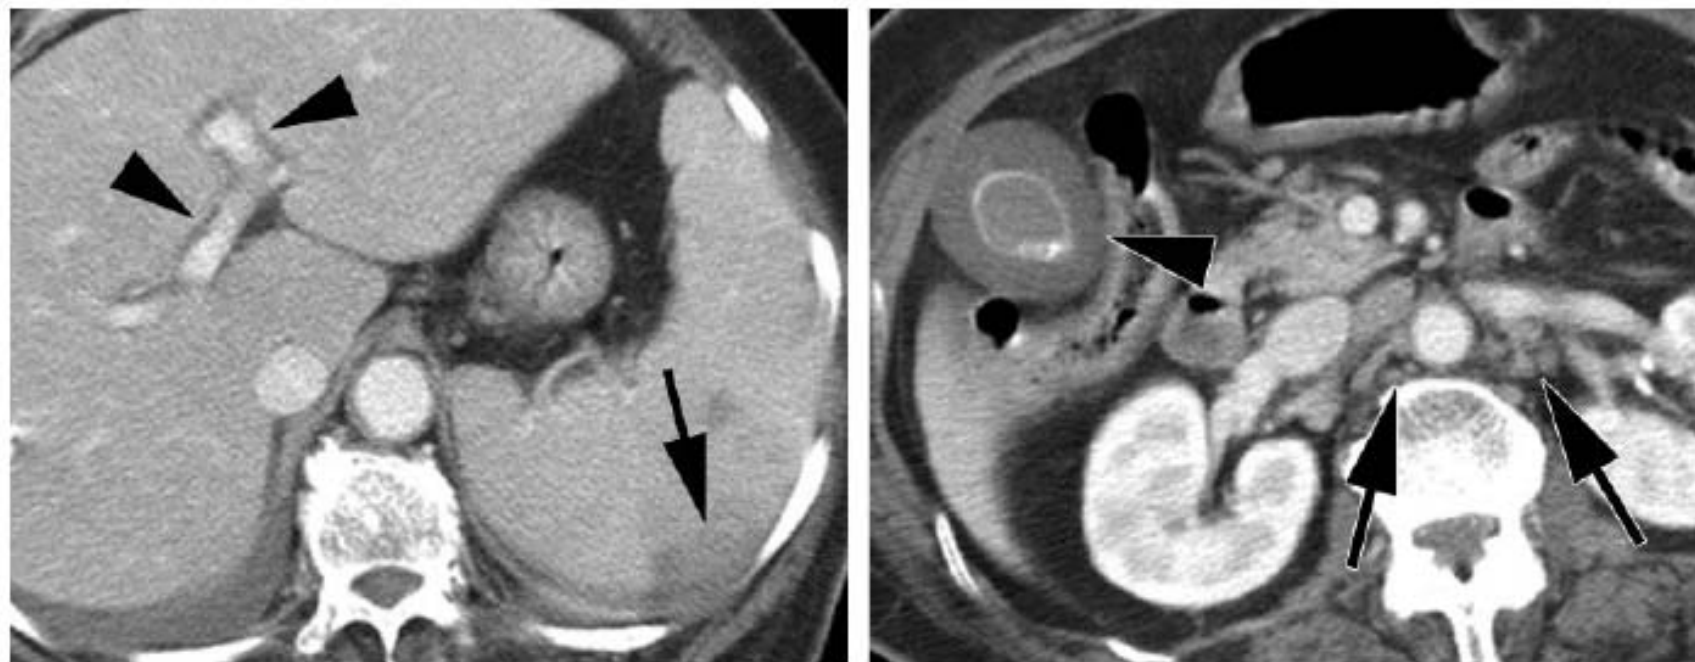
Scrub typhus in a 50-year-old man. Arterial phase dynamic CT images (a at a higher level than b) show mild inhomogeneous enhancement of the hepatic parenchyma as well as splenomegaly.
